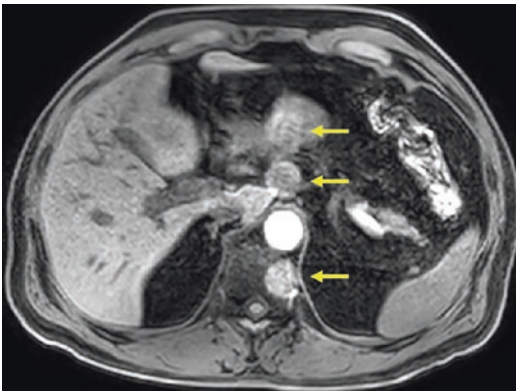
Axial T1-weighted gradient echo Dixon-based fluid image indicates ghost artifacts (arrows) caused by aortic pulsation. Artifacts extend along the anteroposterior, phase-encoding direction
